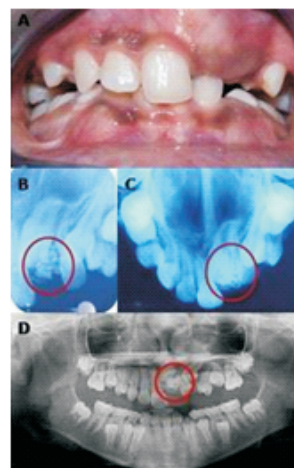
A. Intraoral photograph showing impacted 12. B, C & D. IOPA, occlusal radiograph and OPG revealing dense radiopaque structures overlying 12 suggesting compound odontome.
